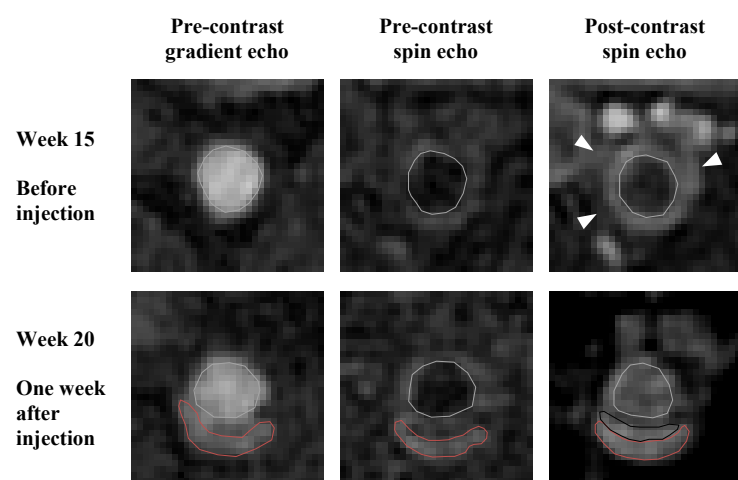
(above). Matching MR images at the location of RBC delivery acquired 4 weeks before (top row) and 7 days after (bottom row) injection. Lumen (grey outline) appears bright in gradient echo images due to inflow while flowing blood is suppressed in pre-contrast spin echo images. Top row: pre-contrast images before injection show vessel wall iso- or hypointense with muscle, indicating absence of pooled methemoglobin. Post-contrast spin echo before injection shows areas of vessel wall contrast enhancement (arrowheads) that indicate plaque neovascularization and inflammation. Bottom row: both gradient echo and spin echo images reveal vessel wall hyperintensity (red outline) characteristic of IPH. Post-contrast image contains additional regions of enhancement (black outline) possibly indicative of increased inflammation and/or neovascularization at this later time point. Each panel is 7.5 mm \times 7.5 mm.
